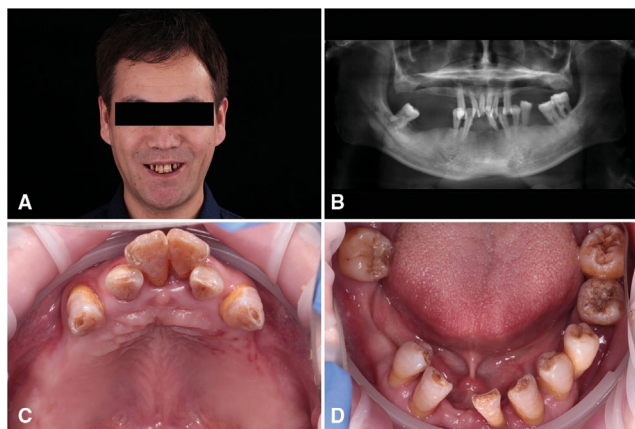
Pretreatment condition. A, Facial photo at smile. B, Panoramic radiograph. C, Occlusal view of upper jaw. D, Occlusal view of lower jaw.
